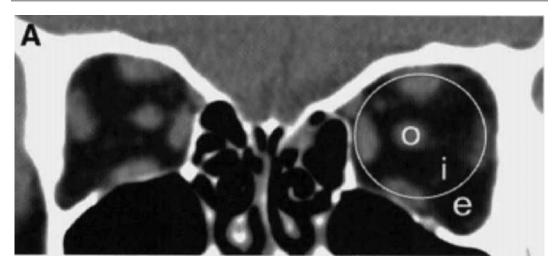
Coronal CT image (soft tissue window) demonstrating bony anatomy and extraocular muscles of the orbit: o optic nerve, i intraconal space, e extraconal space, circle border between intraconal and extraconal spaces formed by connecting the extraocular muscles. *Source* Fig. 1 from van
